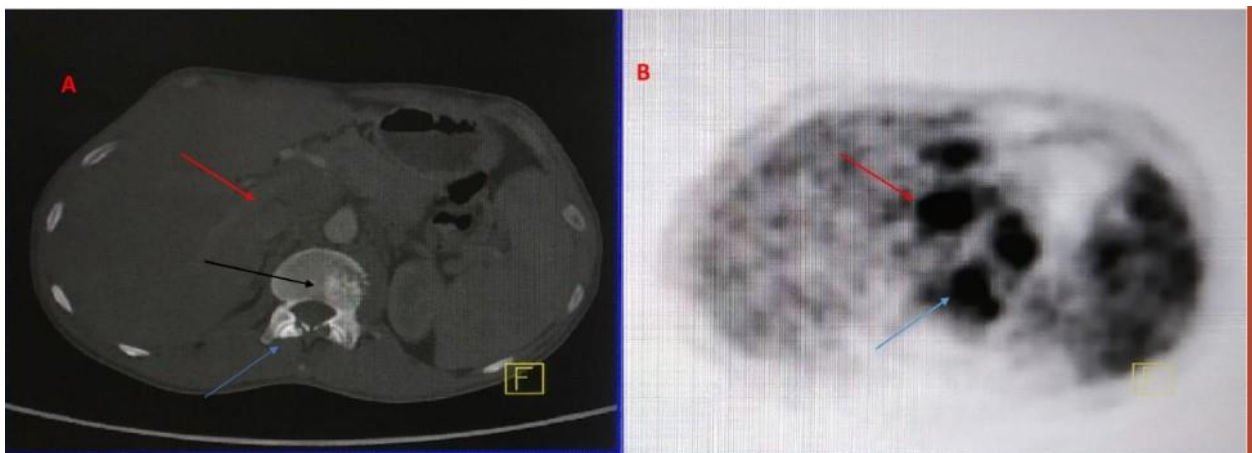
A) Axial CECT image in bone window shows lytic-sclerotic lesion in body and posterior element of L1 vertebra (black & blue arrows) and enlarged aortocaval lymph nodes (red arrow), considered to be lymphomatous involvement; B) Axial PET image shows increased FDG uptake in the L1 vertebra (blue arrow) and aortocaval region (red arrow) considered to be lymphomatous involvement.
